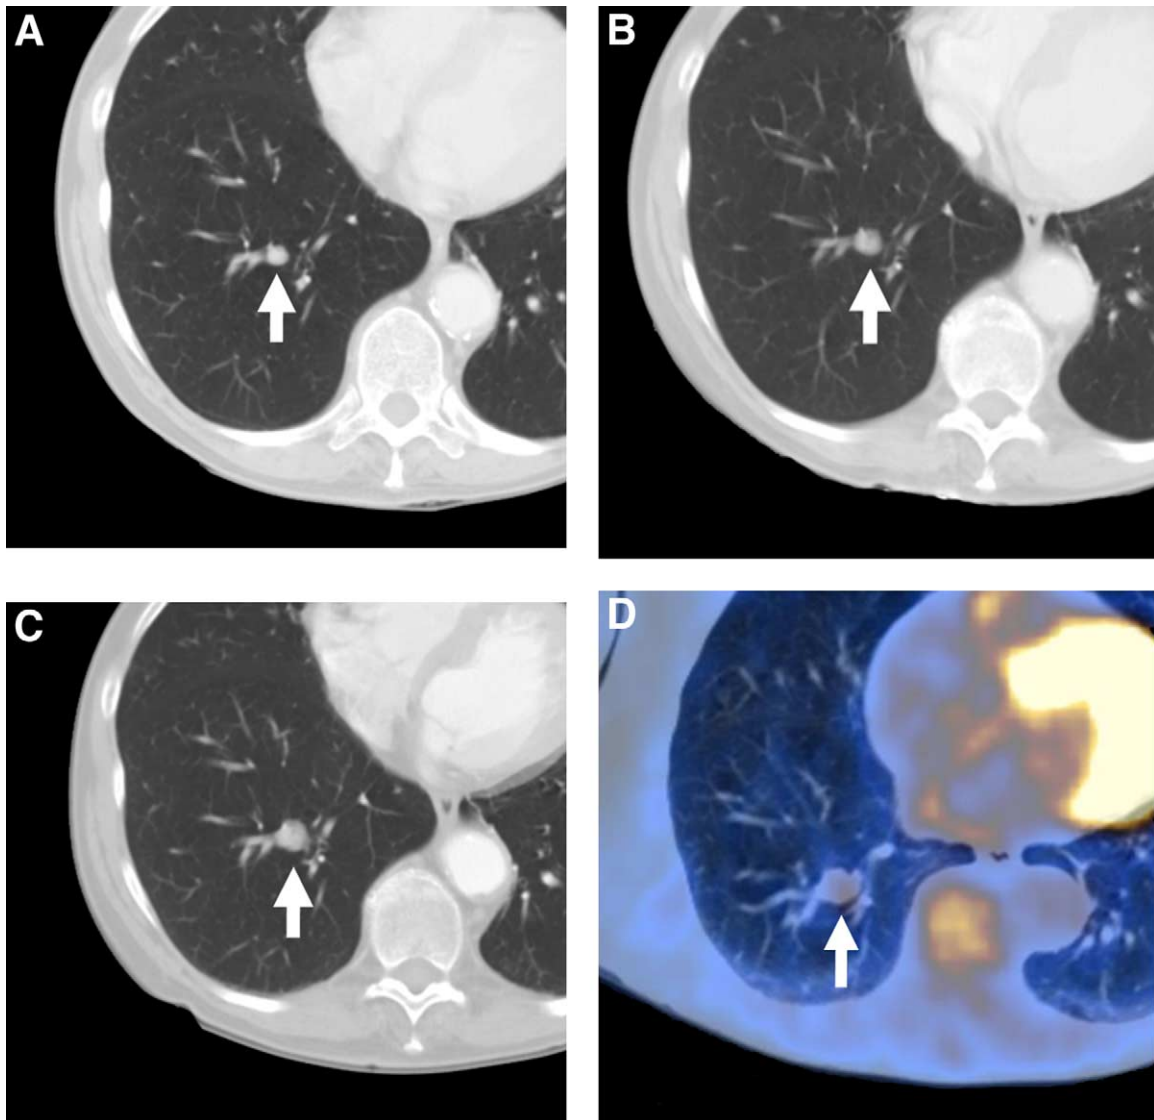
False-negative PET scan. A 68-year-old subject with a history of lymphoma. (A) CT scan obtained for restaging of lymphoma showing a small, noncalcified pulmonary nodule in the right lower lobe (arrow). (B) Follow-up CT obtained 6 months later showing this nodule to have increased slightly in size (arrow). (C) Follow-up CT obtained 1 year after the first showing this nodule to have further increased in size (arrow). (D) PET/CT fusion image from an FDG-PET scan obtained for evaluation of the pulmonary nodule. The nodule is hypometabolic, with activity less than that of the mediastinum. The average SUV of the nodule was 1.5. Because of the progressive growth documented by CT, this nodule was resected and found to be a grade 2 pulmonary adenocarcinoma. All nodes sampled at the time of surgery were negative for tumor.
